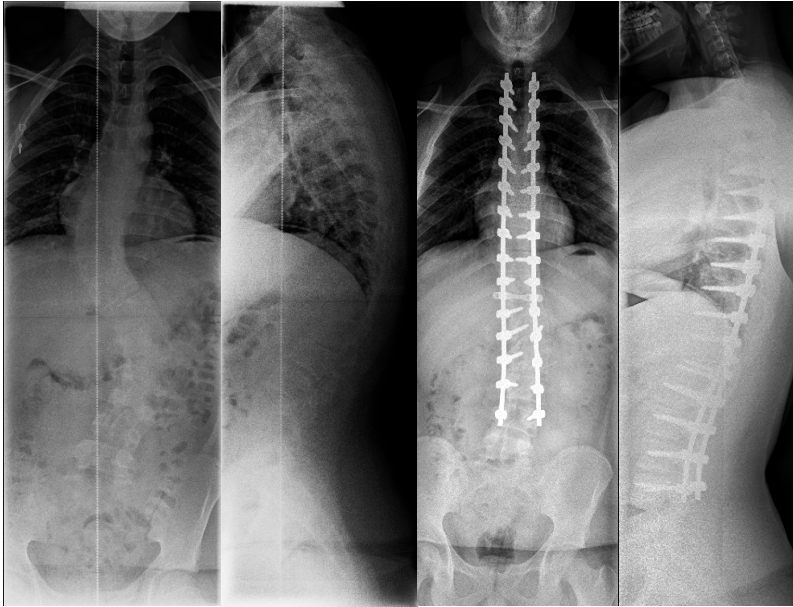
Circular rod instrumentation: Figs. 3-A to 3-D. 14-year-old boy with adolescent idiopathic scoliosis. Preoperative standing radiographs (A, B) demonstrate 59-degree thoracolumbar scoliosis. Standing radiographs at two-year FU (C, D) demonstrate circular rod instrumentation.
